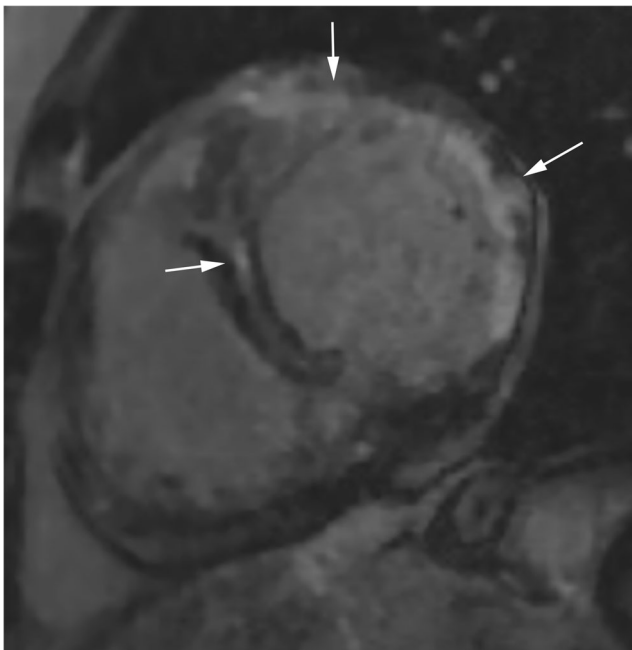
Contrast-enhanced cardiac MRI of an SLE patient shows patchy areas of delayed hyperenhancement in a nonvascular distribution (*arrows*). MRI magnetic resonance imaging, SLE systemic lupus erythematosus
